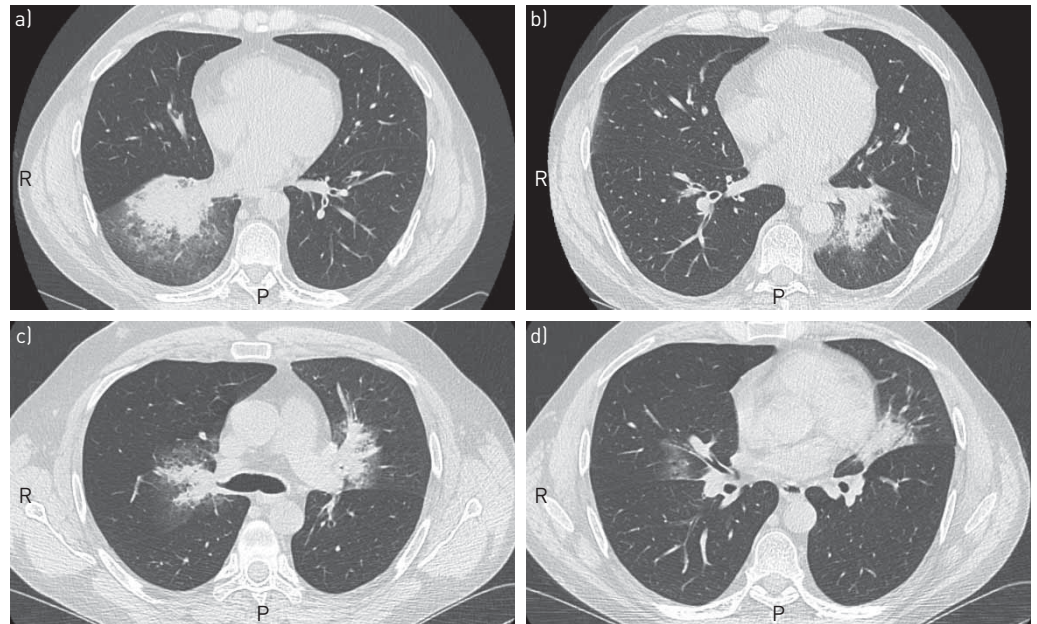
Chest computed tomography (CT) scans in the axial plane the day after bronchial thermoplasty (BT) in the a) right lower lobe, showing peribronchovascular consolidations surrounded by ground-glass opacities, filling of bronchial lumen and mild volume loss of the treated lobe. b) These abnormalities have disappeared 1 month later, when CT is performed the day after BT in the left lower lobe. Similar opacities are observed in this recently treated lobe. c) More limited opacities are observed the day after BT in both upper lobes, performed 1 month later. d) Mild ground-glass opacities are observed at that time in the middle lobe, despite the absence of any activation in this lobe.
